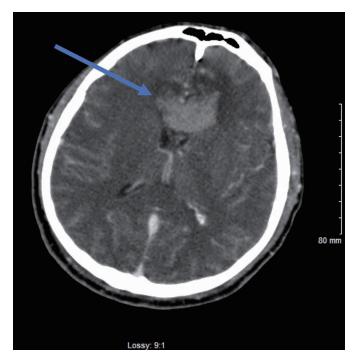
Computed tomography (CT) scan of the head with intravenous (IV) contrast, showing focal hemorrhage versus enhancing mass (blue arrow) involving the genu of the corpus callosum measuring 1.1 \times 1.8 \times 3.9 cm.
